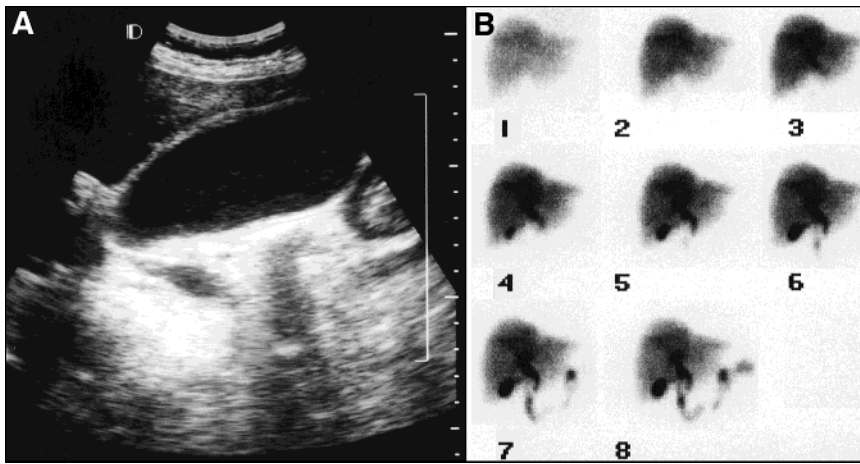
(A) Ultrasound of a patient with congestive heart failure showing a distended gallbladder with thickened walls and sludge. (B) The hepatobiliary scan demonstrates gallbladder visualization and excretion of bile, which are normal findings.
